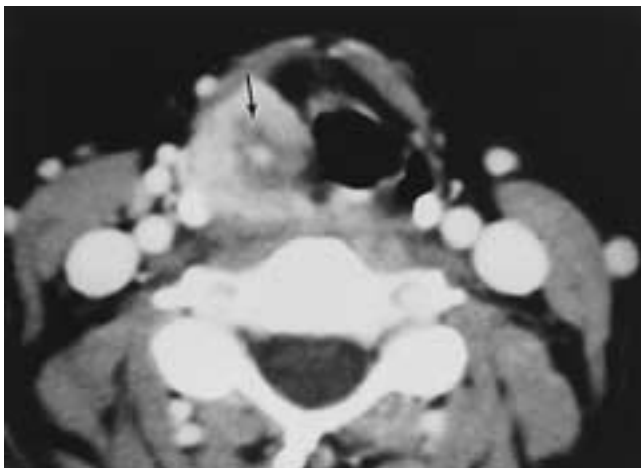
Axial CT of paranglioma of the supraglottic larynx and pyriform sinus shows an enhancing mass in the AE fold and pyriform sinus (*arrow*). (Courtesy of Dr. Peter Som.)
